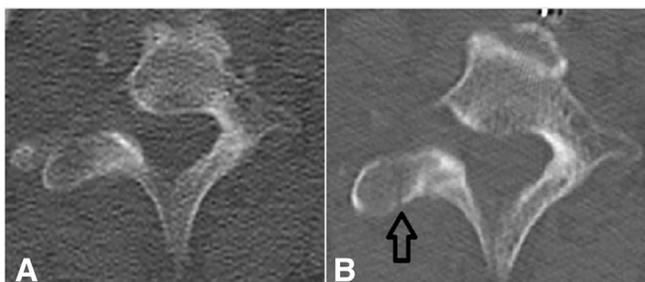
Transverse process fracture occult on body CT. Images shows the T1 vertebra of a trauma patient on the body CT (A) and the spine CT (B). A fracture through the right transverse process was identified on the spine CT, but is not clearly visible on the body CT.
